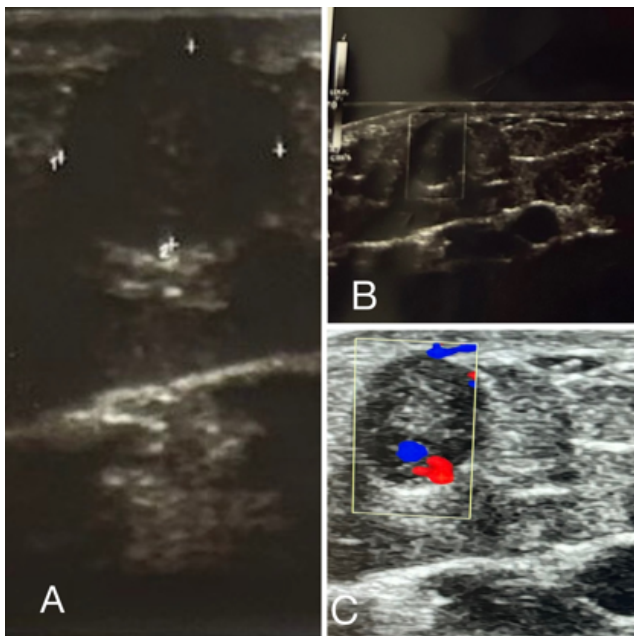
A & B: Ultrasonogram showing a well-defined hypoechoic lesion measuring 0.7x0.7cm in the subcutaneous plane (A & B) with colour doppler image showing internal and peripheral vascularity (C).
